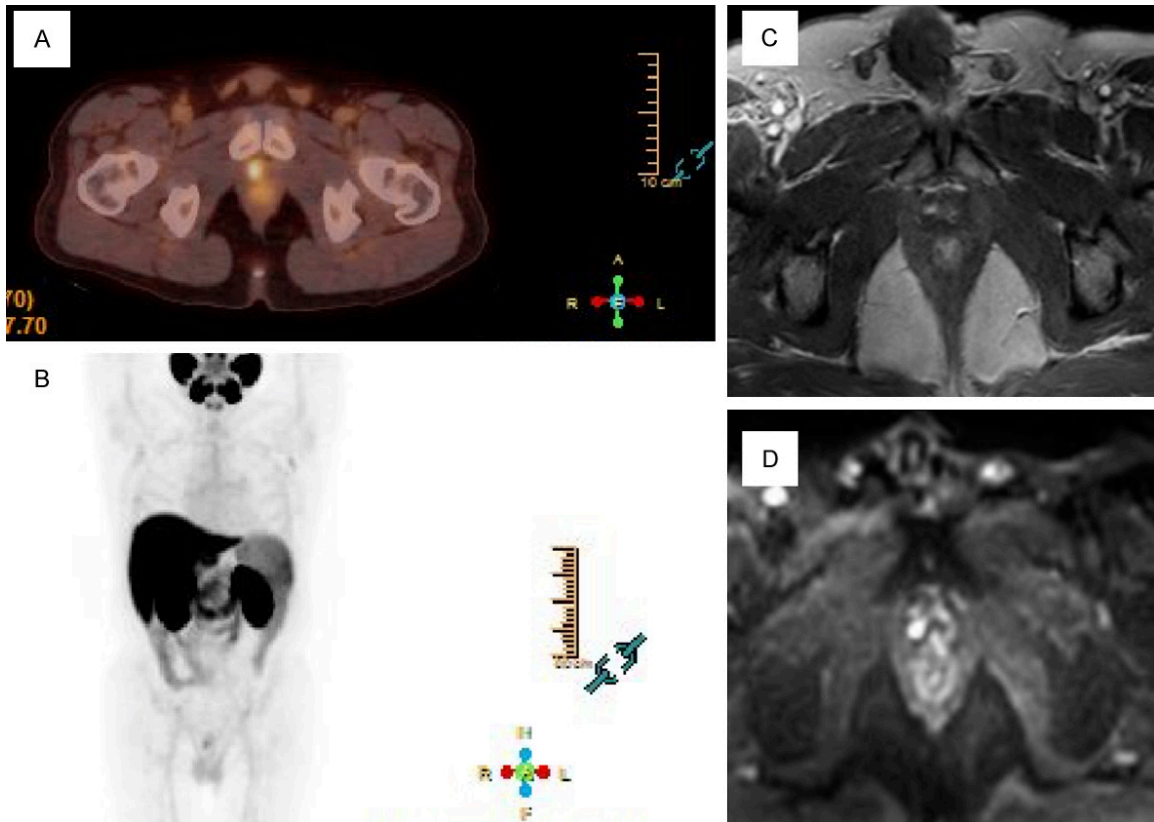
^{18}F -PSMA-1007 PET/CT (A, B) and MRI (C, D) of a 57 years old patient 4 years after radical prostatectomy. The PSA level at the time of the study was 0.38 ng/ml. (A, B) ^{18}F -PSMA-1007 accumulation in the prostate bed, correlating with local recurrence. DCE (C) and DWI (D) MRI reveal a lesion in the prostate bed with early contrast enhancement and diffusion restriction, respectively.
